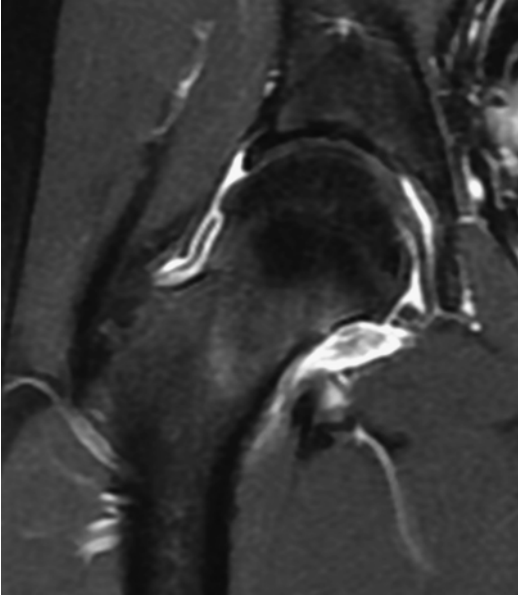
MRI coronal view (T1-FS-gadolinium) of the right hip: pathognomonic hemosiderin deposition signal of a villonodular synovitis
